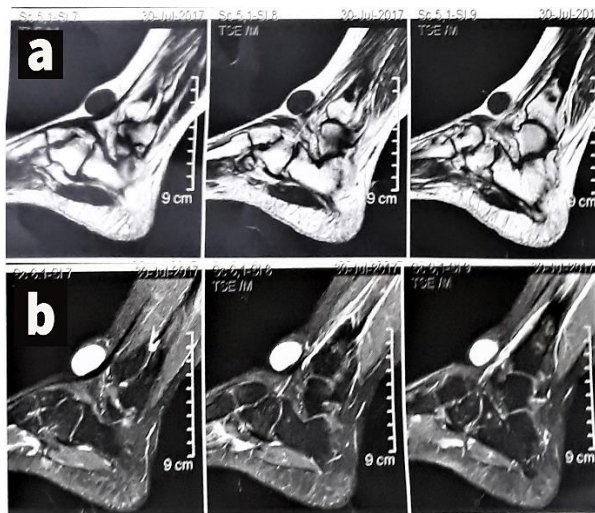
a) Sagittal T1-weighted images of the left ankle soft tissue mass with hypointensity of the lesion; b) Sagittal T2-weighted images with hyperintensity of the mass
